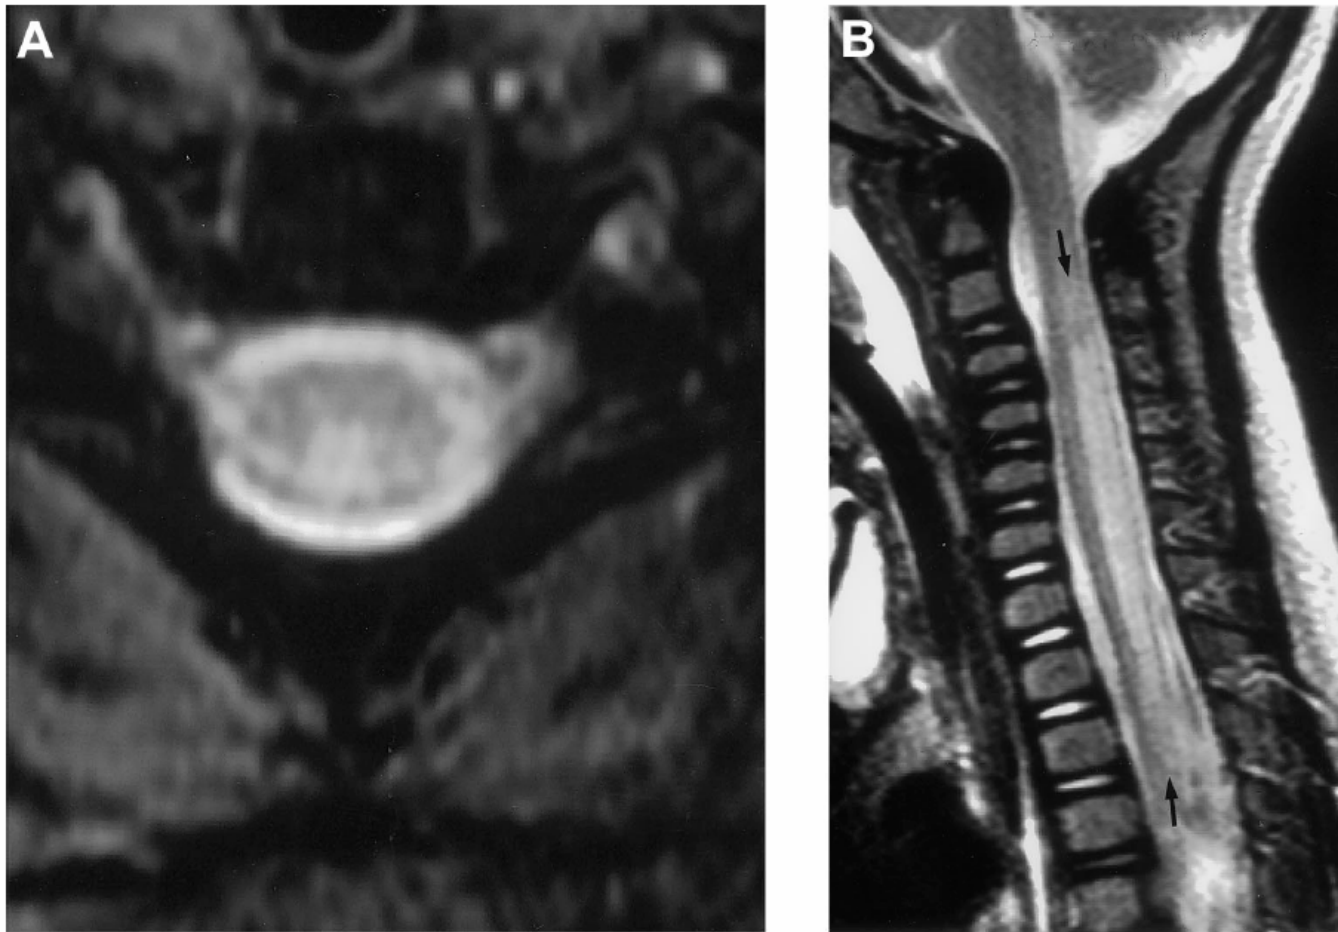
MRI of a 9-month-old female infant (patient 2) with enterovirus 71–associated neurological disease. *A*, axial gradient-echo T₂-weighted MRI done 3 days after the onset of acute transverse myelitis, showing a high signal lesion centered in the dorsal column white matter of the cervical cord. *B*, midsagittal turbo spin-echo T₂-weighted MRI scan done during the same examination as in *A*, showing a lesion from C2 to T2 (arrows) with mild cord expansion.
